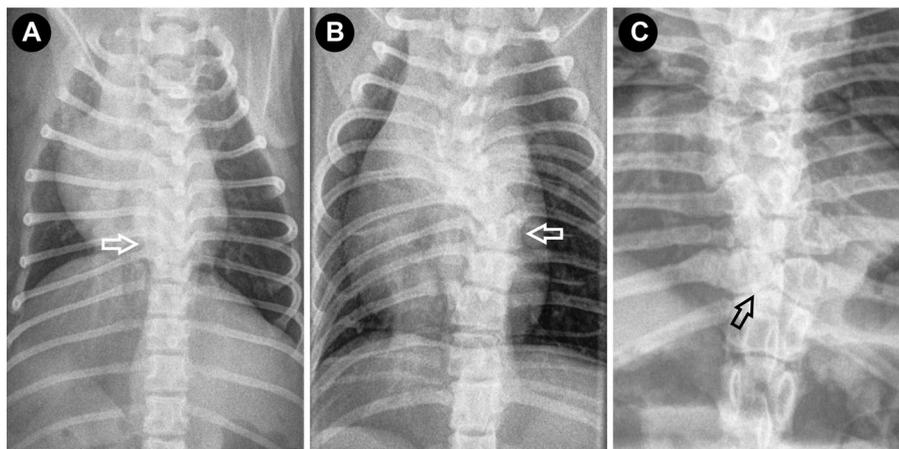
Congenital vertebral malformations identified on ventro-dorsal radiographs of the thoracic vertebral column. (A) Ventral hypoplasia of T8 vertebral body (arrow, this is the same case as figure 2B); no evidence of scoliosis is evident on the ventro-dorsal view if there is no lateral hypoplasia. (B) Ventro-lateral aplasia of T8 vertebral body (dorso-lateral hemivertebra) (arrow). This case had similar changes to figure 2C on the lateral view. (C) Ventral and median aplasia of the vertebral body (Butterfly vertebra) (arrow).
